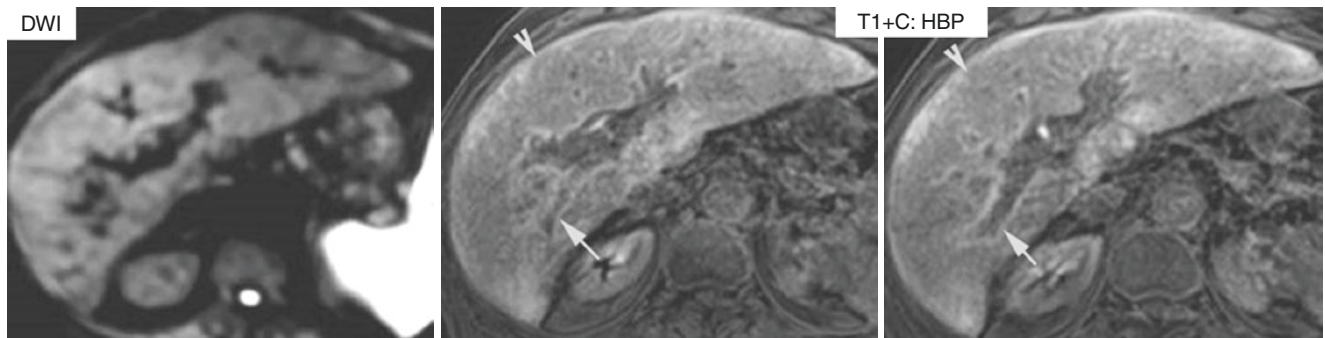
Liver MP MRI evaluation in a patient with hepatocyte dysfunction related to SOS after chemotherapy: comparison between DWI and hepato-biliary phase after Gd-EOB-DTPA i.v. injection: periportal
